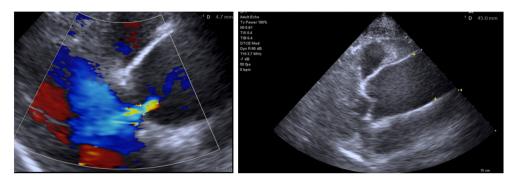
b.14. AR with central flow in a case with ascending aortic aneurysm (45 mm) (color Doppler and 2D, parasternal long axis view)
